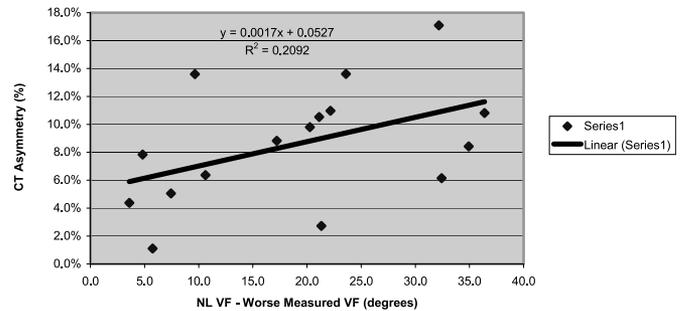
Degree of CT asymmetry (%) versus amount of visual field constriction (degrees).
